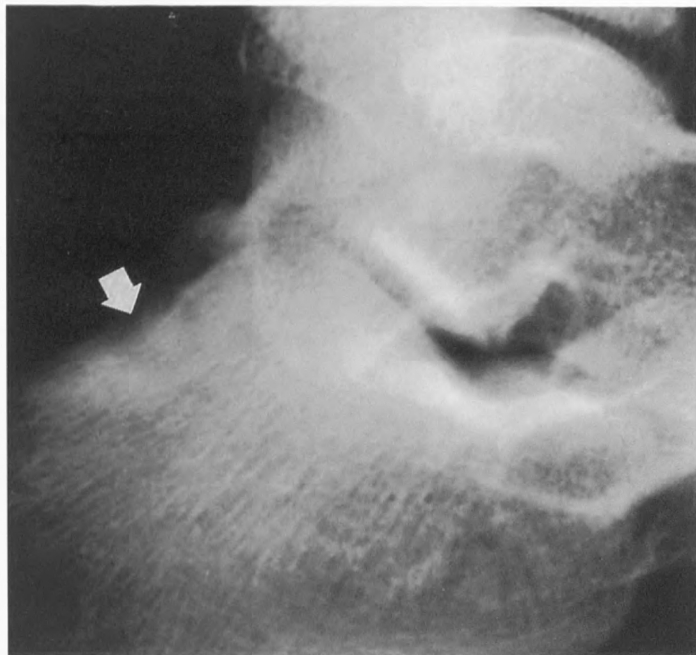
Plain radiograph of the lesion in the calcaneus. There is a radiopaque nidus (arrow) with a radiolucent halo surrounded by a sclerotic rim of reactive bone in the superior-posterior calcaneus. Radiopaque areas appear light or white on the exposed film; radiolucent areas appear dark on the exposed film. (Note: Nidus is the point of origin or focus of a morbid process; halo is a luminous or colored circle; and a sclerotic rim is hard or hardening bone).
